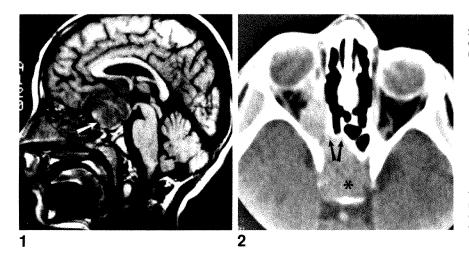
T1-weighted sagittal MR image, 600/20. Large chiasmal pilocytic astrocytoma with downward extension into pituitary fossa and sphenoid sinus (arrow).
